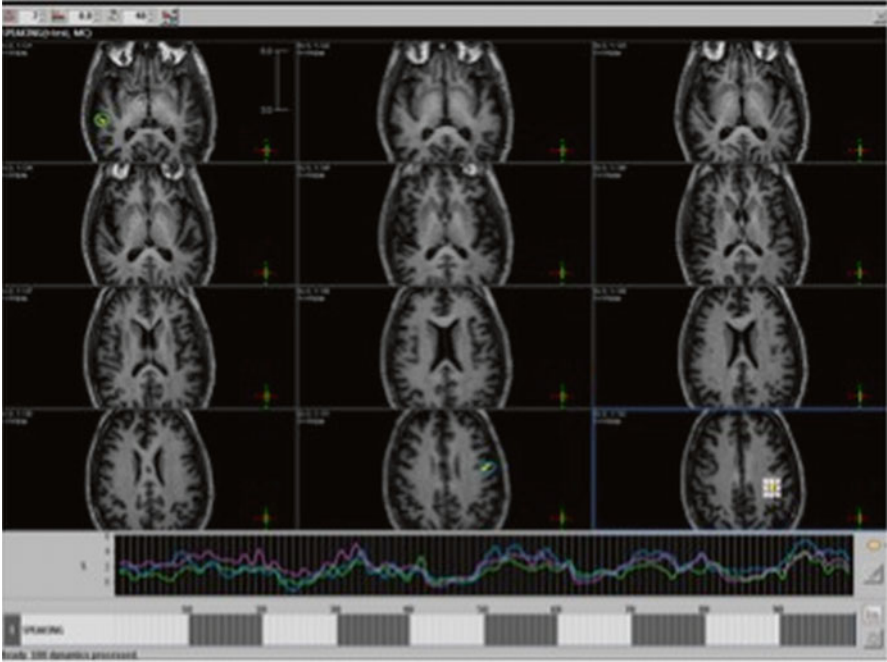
Functional MRI showing bilateral, temporal language representation
